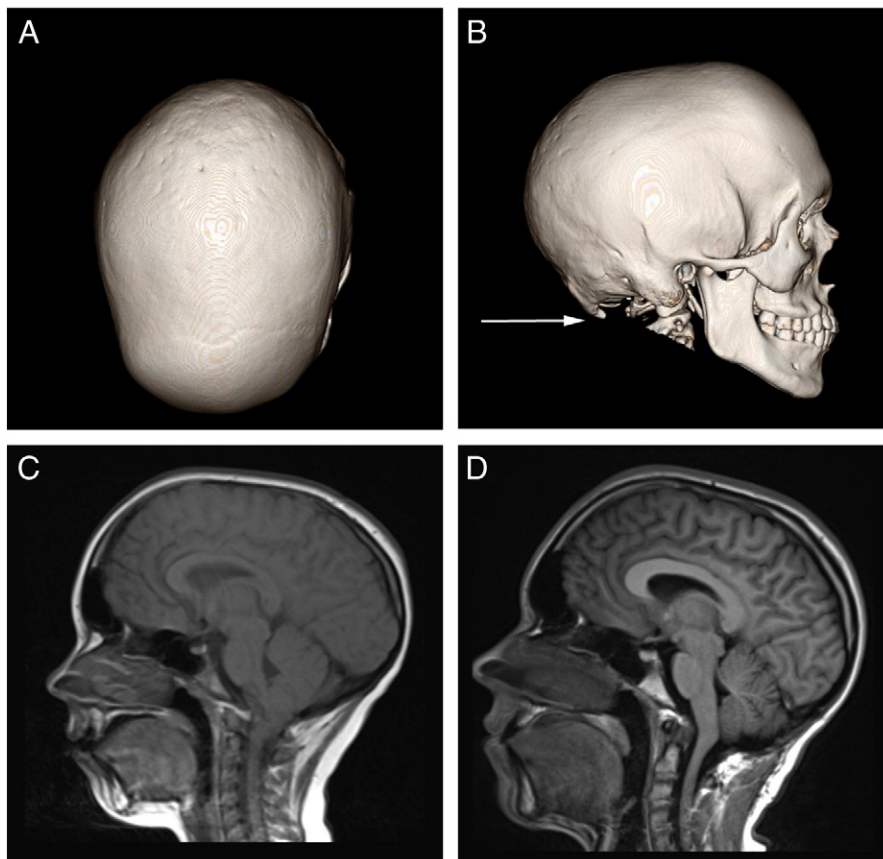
Pre-operative superior (A) and lateral (B) views of the calvarium on CT scan demonstrating suture fusion and a bony spur at the site of a prior Chiari decompression. T1-weighted MRI scan (C) revealing a Chiari malformation five years prior to his craniofacial workup and post-operative MRI (D) demonstrating decompression of the Chiari malformation.
